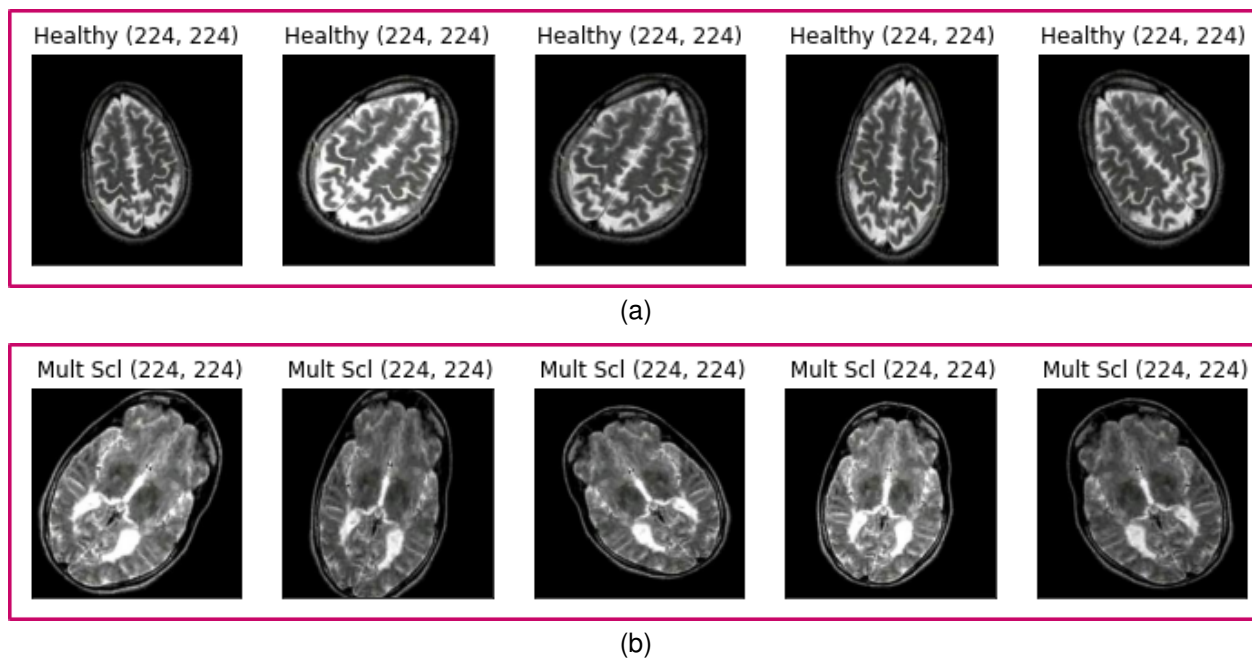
Preprocessing steps involve cropping the brain MRI image
